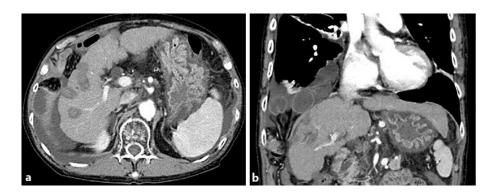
CT on admission. Diaphragmatic herniation of bowel loops into the right thorax is observed in horizontal (a) and coronal (b) images.
